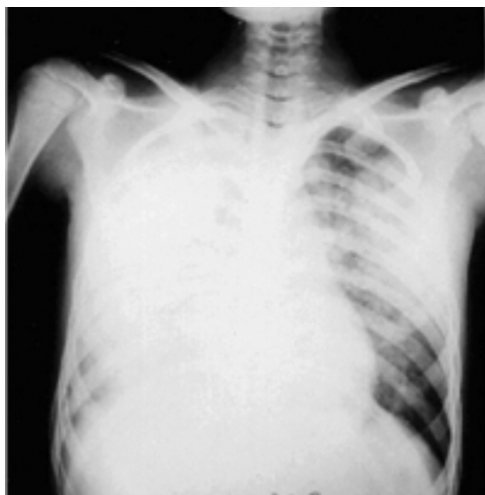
Chest x-ray taken four hours after *Odontobuthus doriae* sting showing diffuse, fluffy, bilateral infiltrates, which are predominantly in the right hemithorax.
